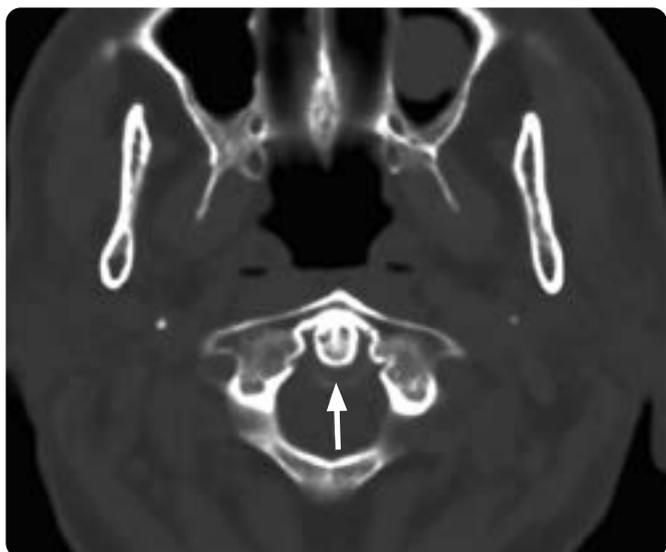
Crania-cervical junction CT: lentiform calcification surrounding the odontoid process (arrow).
